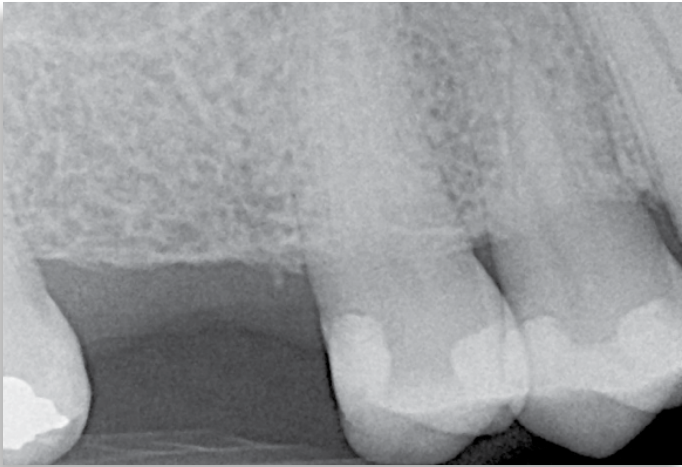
Periapical of edentulous maxillary right first molar area. How much vertical and height of bone do we really have?
